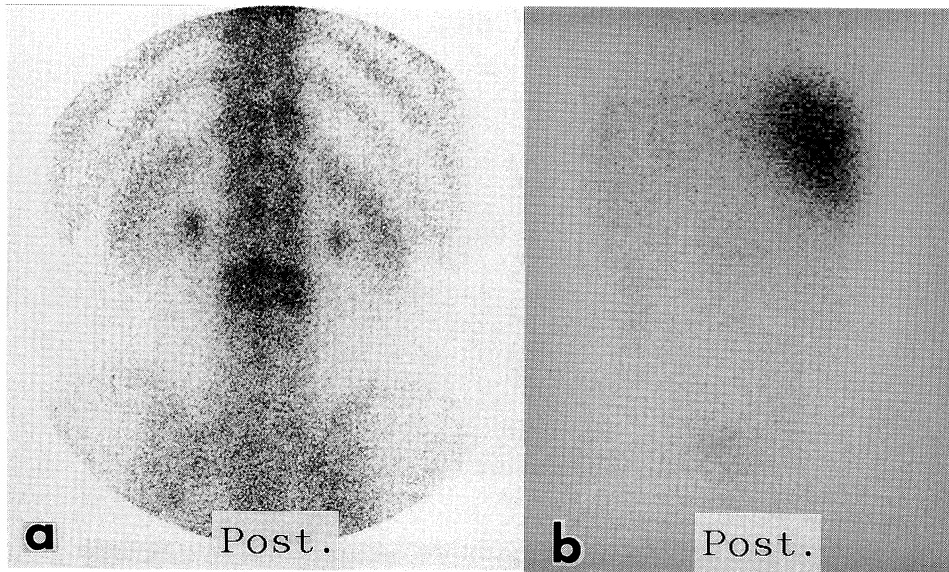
Follow-up bone (a) and ^{67}Ga (b) scintigraphies performed two years after the initial scintigraphies. Both studies demonstrate decreased accumulations in the third lumbar vertebra.
